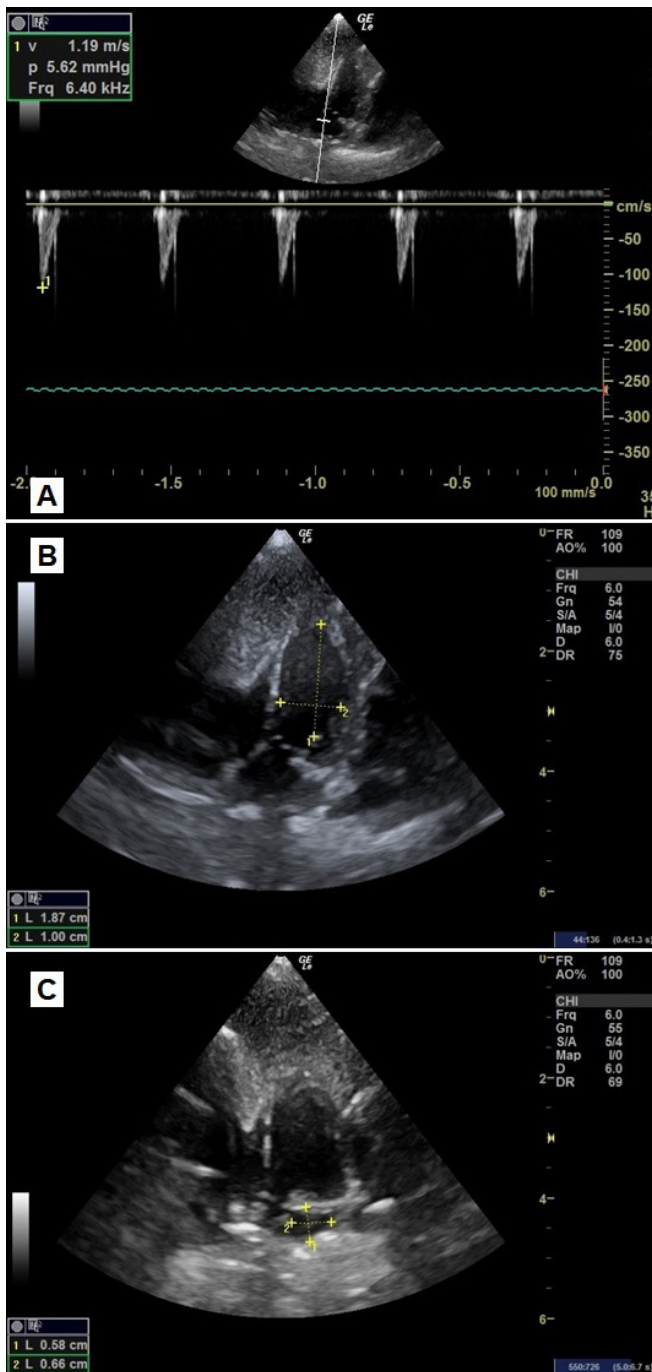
Echocardiographic findings of *Amazona aestiva* subjected to chemical restraint with midazolam (0.2 mg/kg) associated with ketamine (25 mg/kg) (PMK protocol). (A) Aortic flow obtained using the horizontal ventromedian approach; (B) Left ventricular internal length in diastole (LAVd) through apical four-chamber view obtained via the horizontal ventromedian approach; (C) Left atrial internal length in diastole (LALd). Longitudinal lines represent the length, and transverse lines represent the left ventricular diameter.
